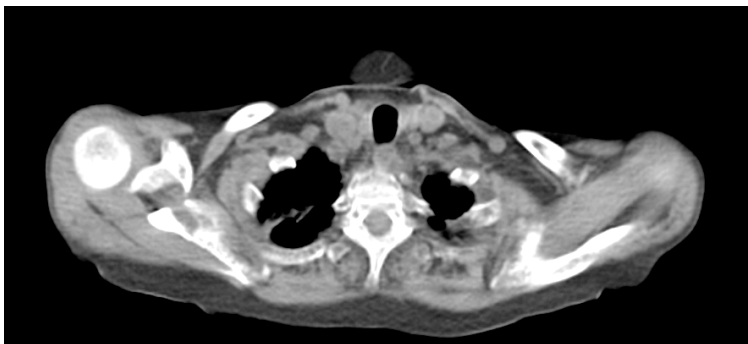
CT (non-contrasted) demonstrated a right-sided apical, pleural-based nodule with the following measurements: 32 x 11 mm. No definite diagnosis could be made.
